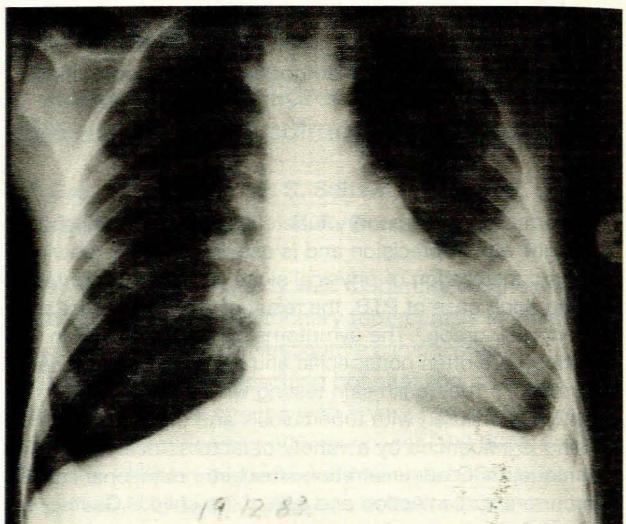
Chest radiograph of a 7-year-old boy with pulmonary infiltrates with eosinophilia. Dense opacification of the lingula is present, which cleared on steroid therapy.
